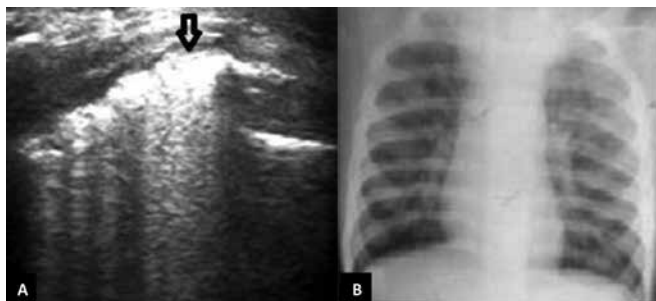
(A) Lung ultrasound showing confluent B lines with overlying thick and irregular pleura (arrow); (B) chest radiograph of the same child showing infiltrates in the left upper-zone.
